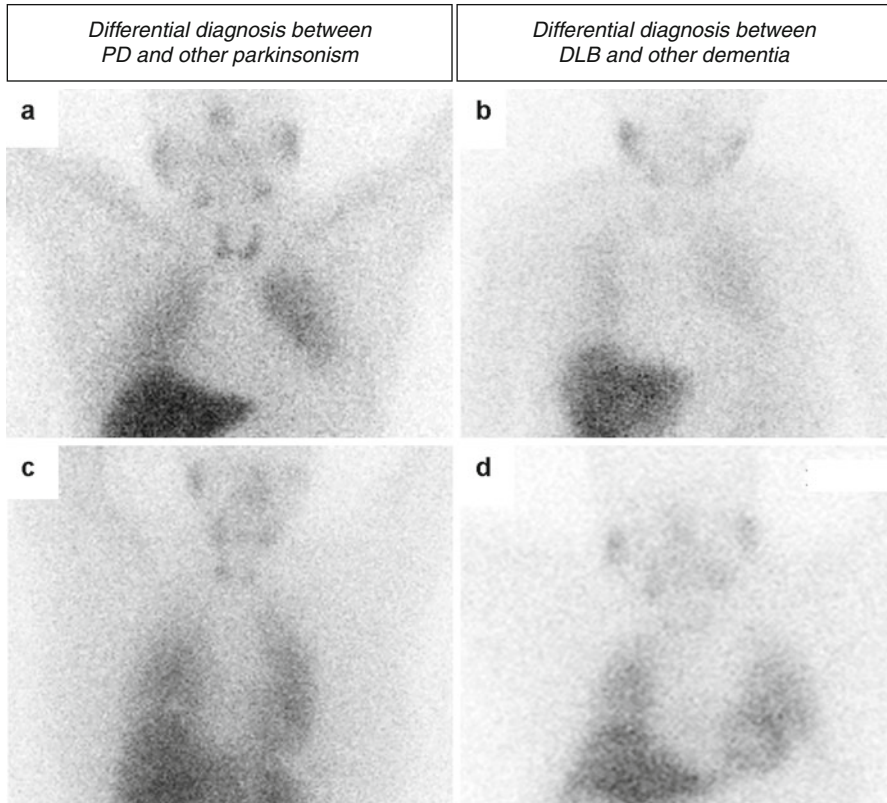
[^{123}I]-MIBG scintigraphy (planar imaging performed at 4 h after tracer injection) showing abnormal myocardial uptake in a patient with Parkinson's disease (a) and in a patient with dementia with Lewy body (b), and normal myocardial uptake in a patient with multiple system atrophy (c) and in a patient with Alzheimer's disease (d), demonstrating myocardial sympathetic impairment in patients with Lewy body disease (a, b) and normal myocardial sympathetic innervation in other neurodegenerative diseases (c, d)
